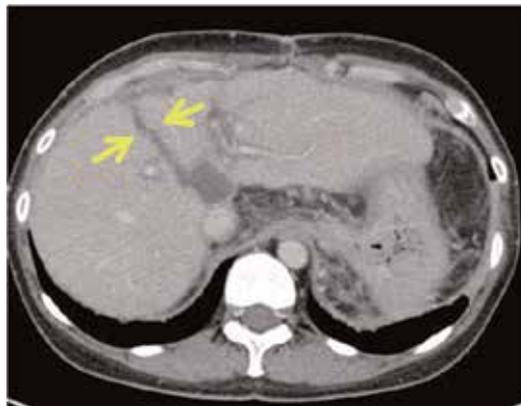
Follow-up CT of Patient 1 two months after the surgery Yellow arrows indicate the dividing plane between the right and left hemilivers.
